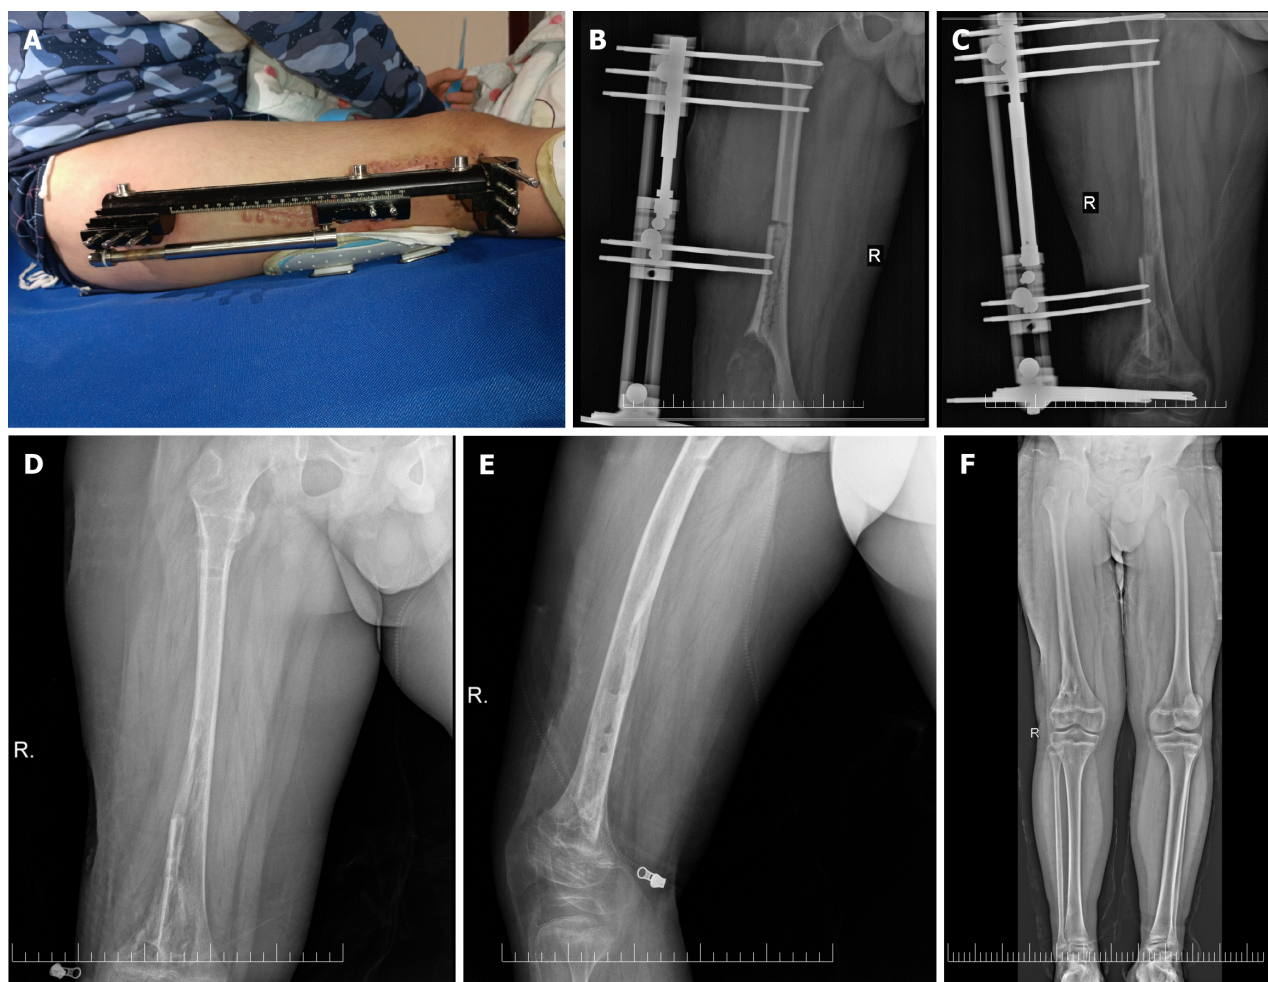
Postoperative follow-up photos. A: Photo at review; B: Anterior-posterior X-ray image of the right knee four days after surgery; C: Anterior-posterior X-ray image of the right knee five months after surgery; D: Anterior-posterior X-ray image of the right knee after remove the external fixator; E: Lateral X-ray image of the right knee after remove the external fixator; F: Anterior-posterior X-ray image of the lower limbs.
